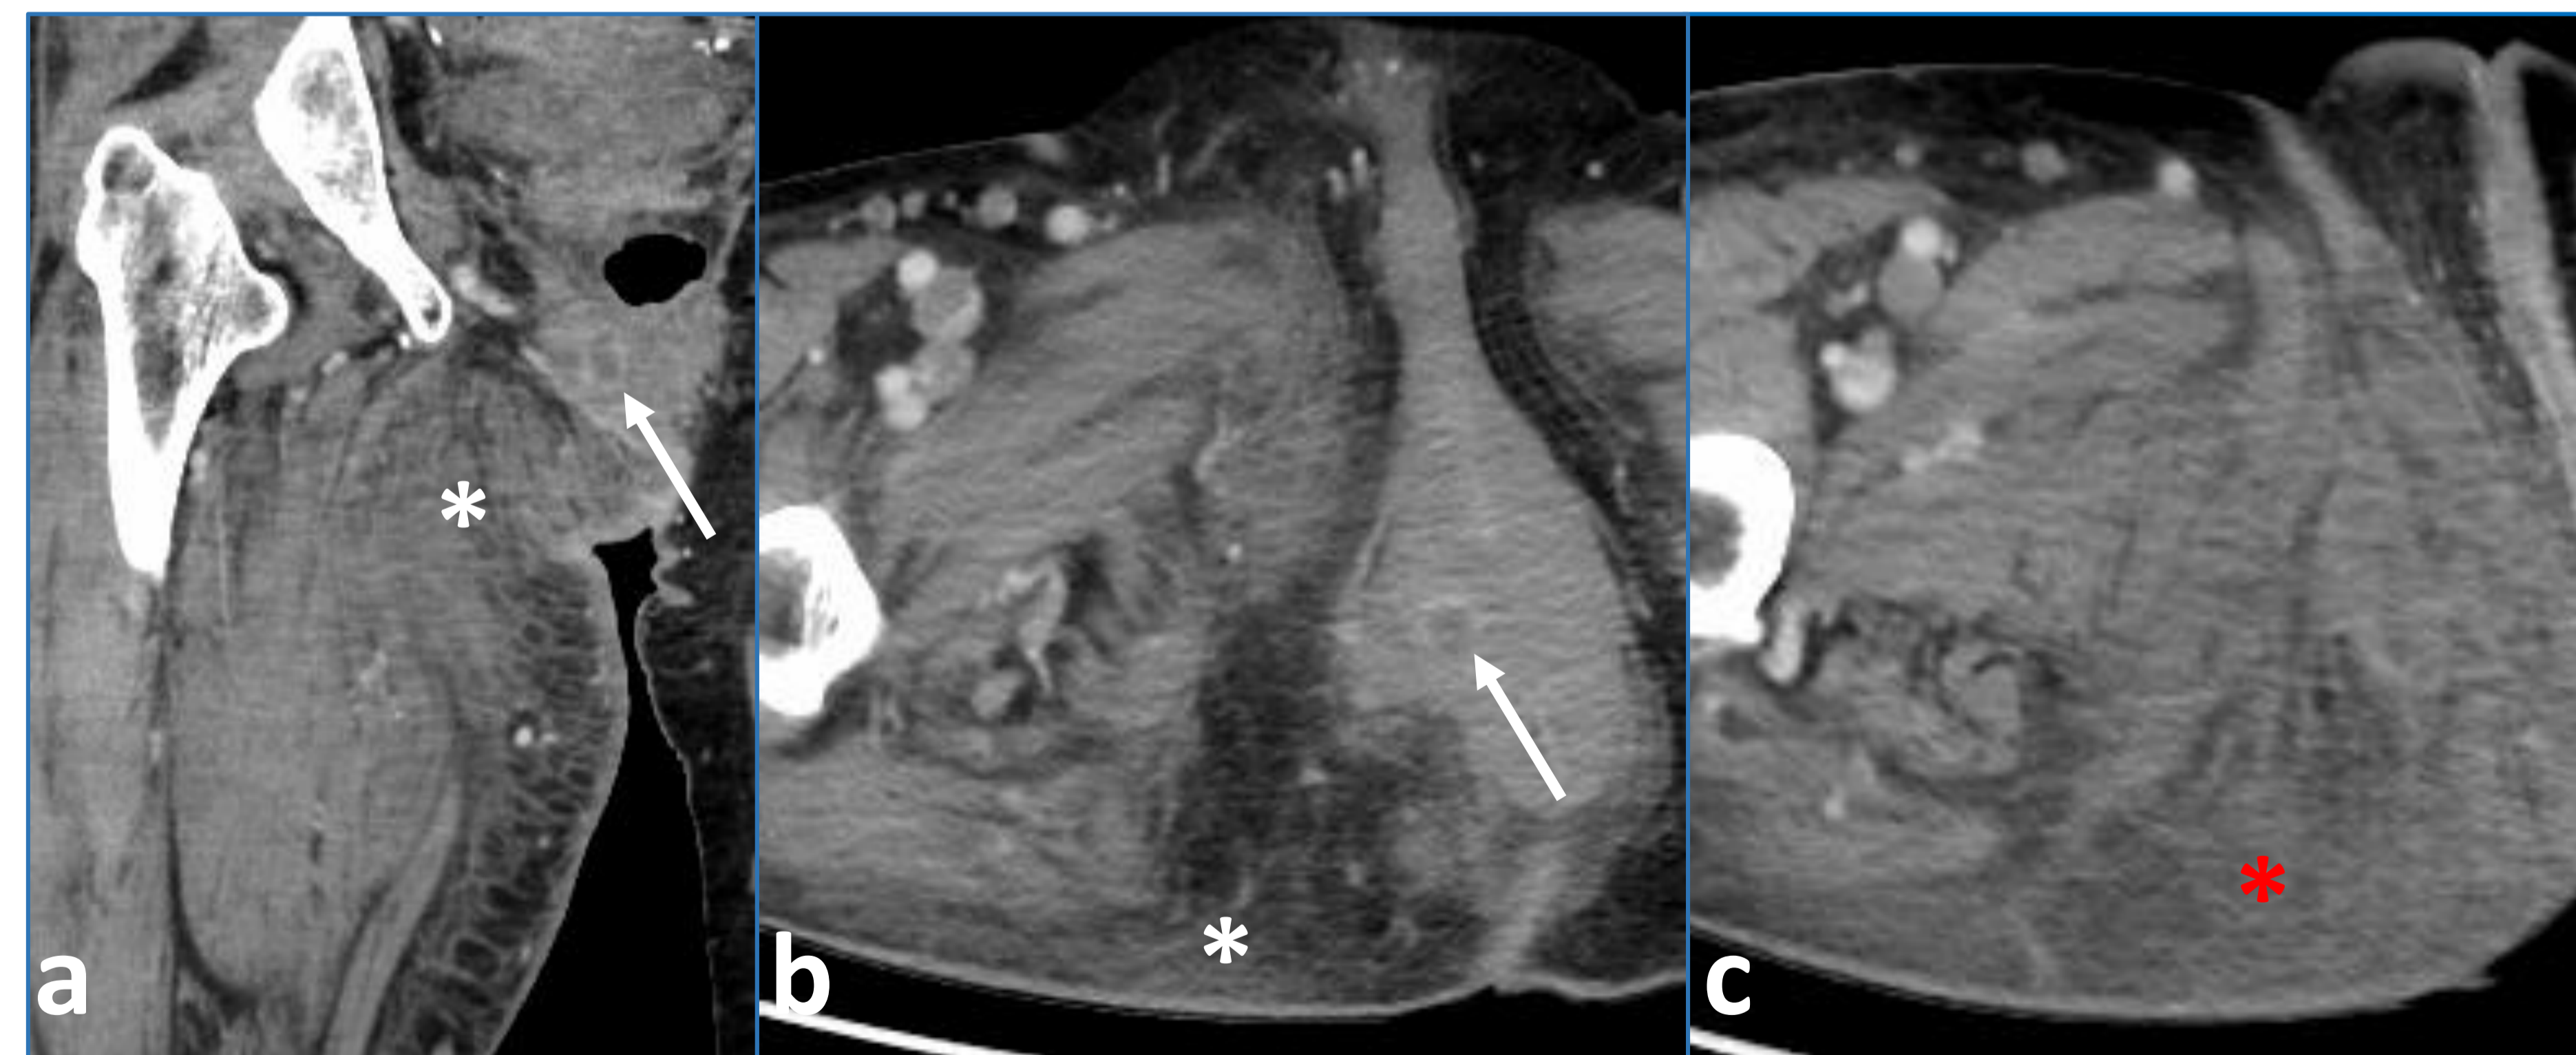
Fournier's gangrene in female. a, b coronal and axial CT images show a small periurethral abscess (arrow) with extensive fat stranding along right-sided perineum and right buttock (*). c axial CT image at lower section also shows extensive fat stranding at medial thigh (*).
